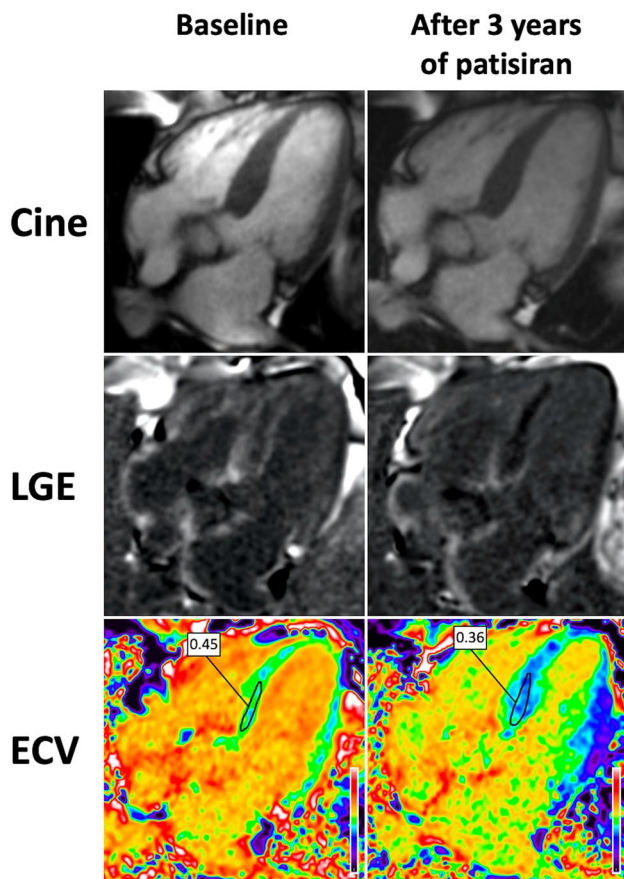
Cardiac magnetic resonance imaging demonstrating cardiac regression following 3 years of treatment with patisiran. Following 3 years of treatment there has been a reduction in the amount of subendocardial late gadolinium enhancement and a reduction in the extracellular volume. *Cine* imaging sequence acquired to capture motion, *ECV* extracellular volume, *LGE* late gadolinium enhancement
